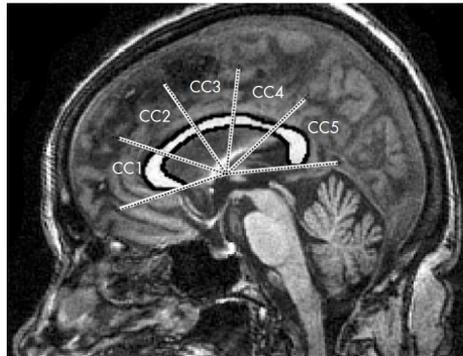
Example of mid-sagittal magnetic resonance imaging slice with 5 subdivisions of corpus callosum. Image originates from [2].
